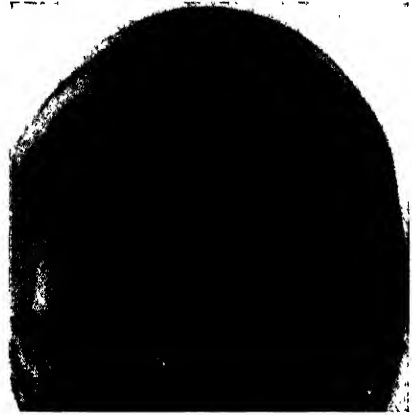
Skull X-ray in Towne's position showing thorotrast in a collapsed cerebellar abscess which is at the apex of the petrous bone.
